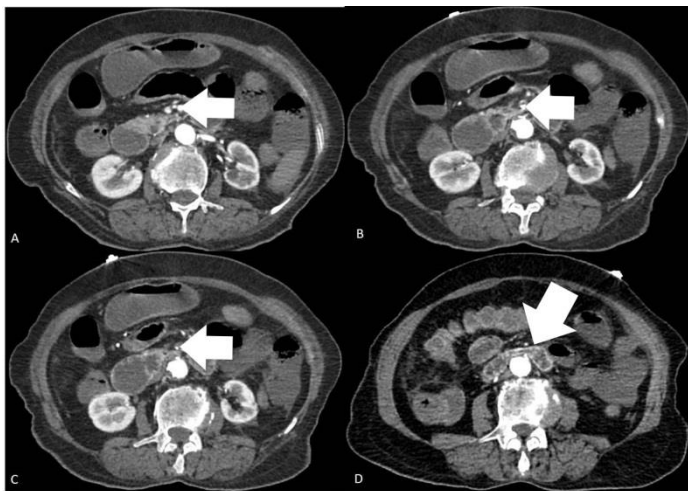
A: Contrast enhanced abdominal computed tomography shows patent superior mesenteric artery (arrow), B, C: Contrast enhanced abdominal computed tomography; there is thrombosed superior mesenteric artery (arrow), D: There is a narrow segment of duodenum between superior mesenteric artery and abdominal aorta (arrow)
